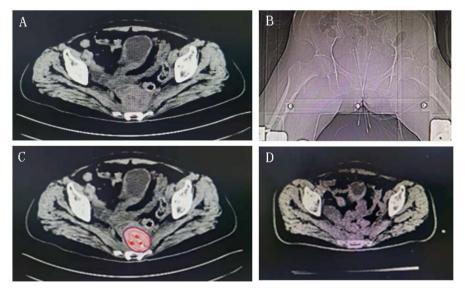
(A) CT showed a small pre-sacral recurrent mass that had increased signify-cantly in size over 3 months; (B) Radiation therapy with brachytherapy interposition was given; (C) HRCTV with brachytherapy was highly conformal to the pre-sacral recurrent mass; (D) CT showed a significant reduction of the mass after 24Gy/4 fractions of brachytherapy.
